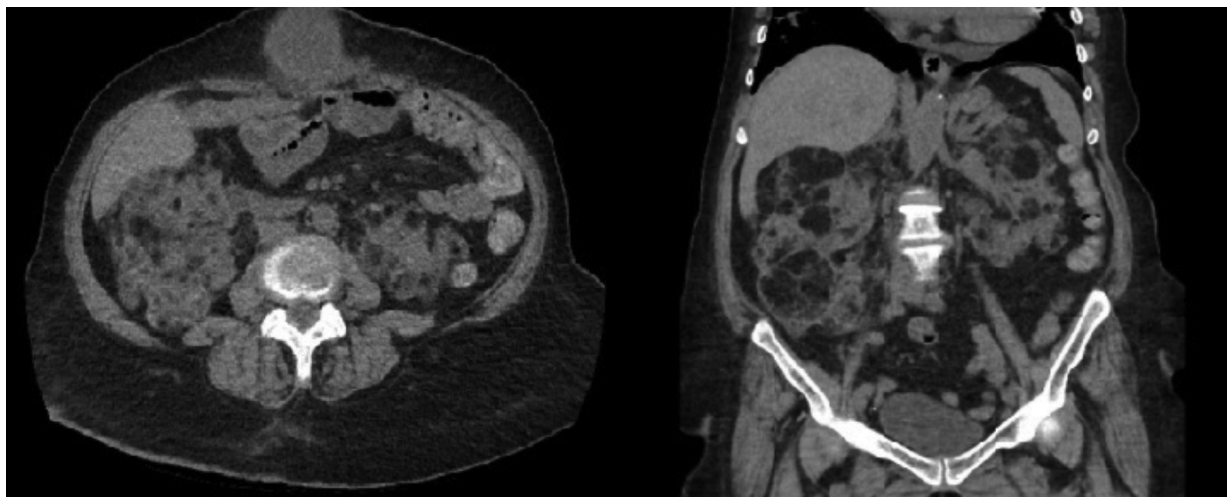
Control CT image at one year after the procedure
